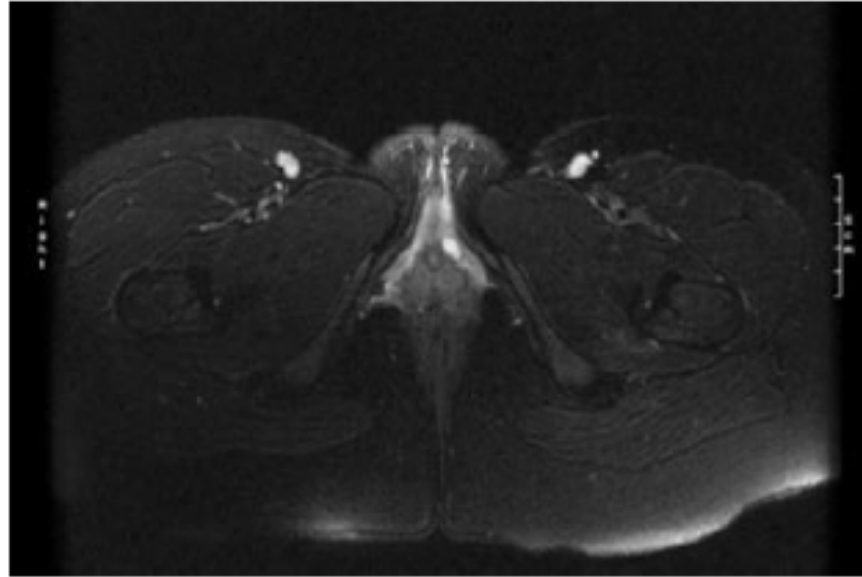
Axial section MRI of patient no. 2 with the oval glandular tissue at the left side of the middle urethra (anterior) [60].
